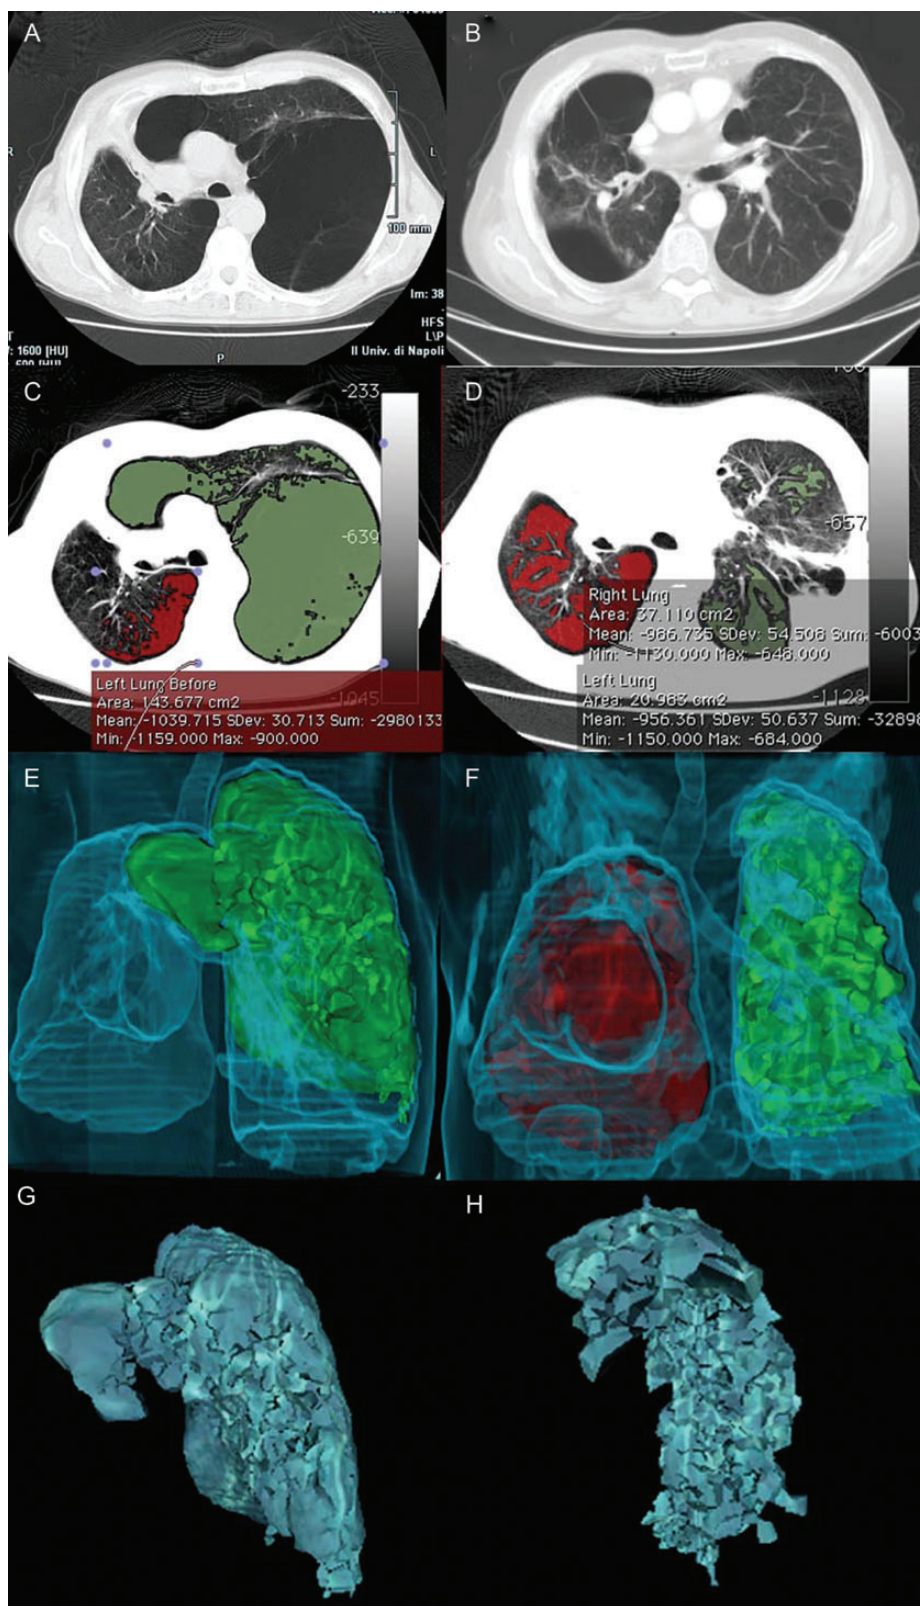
A 65-year old man presented a giant emphysematous bulla that occupied the entire left lobe (A). The axial computed tomography (CT) scans obtained at the same level after endobronchial valve treatment (B) showed the complete atelectasis of the bulla with subsequent re-expansion of adjacent parenchyma; the volumetric difference was appreciated on the same CT slices before (C) and after (D) treatment. Then, a 3D region growing algorithm was applied with subsequent superimposition of ROI masks (qMDCT) in the range of $-1.024/-950$ HU; virtual rendered (VR) images of volumes were obtained before (E) and after (F) treatment to easily represent the volume reduction, as calculated using a dedicated algorithm, to obtain a volumetric quantitative measurement. Finally, corresponding volumes obtained before (G) and after (H) treatment were shown after applying a 3D mesh to visualize previously segmented areas of each lung.
